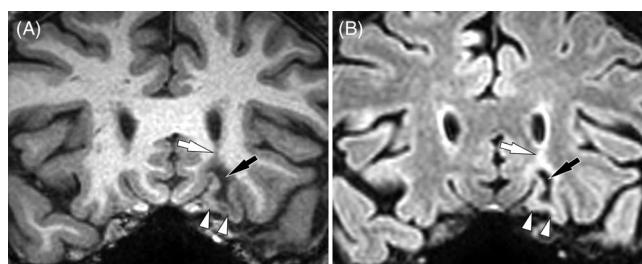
Coronal MR images of low signal intensity lesion (black arrow) centered in the white matter of the left medial orbitofrontal gyrus on MPRAGE T1-weighted (A), and T2 FLAIR (B) images. Features include lack of enhancement on T1-weighted MRI (not shown), high T2 signal (not shown). The extension of signal abnormality to the left frontal horn (white arrows) mimics the transmantle sign of cortical dysplasia. The cortical gray matter overlying the lesion is intact (double arrowheads) which would not be expected in post-traumatic or post-infarct encephalomalacia.
